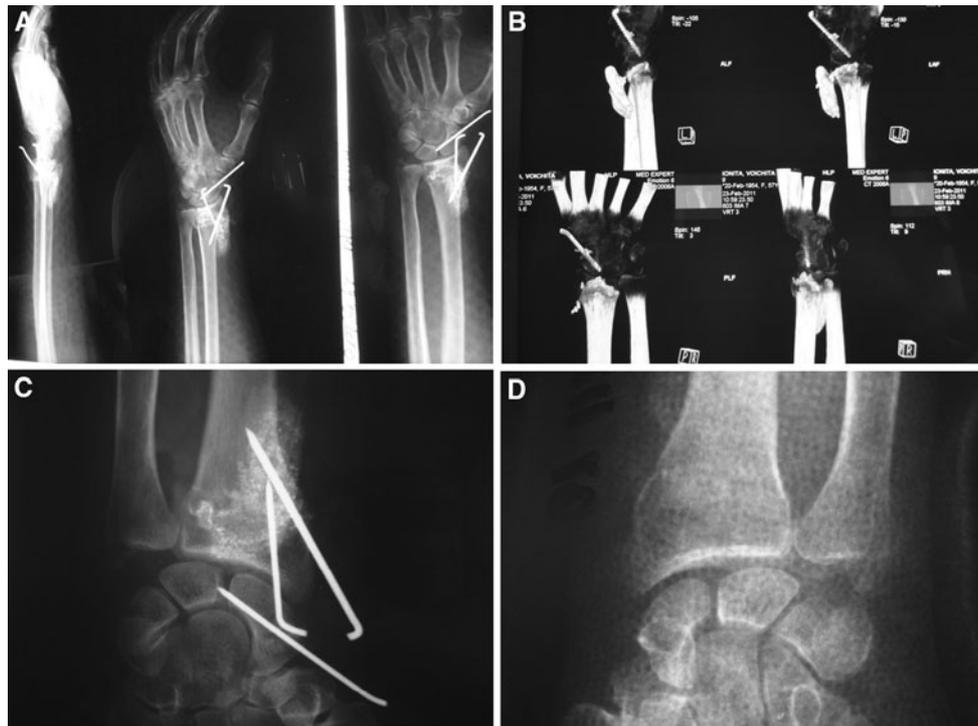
Distal radial fracture associated with a carpal scaphoid fracture—orthopaedic reduction, percutaneous temporary fixation with K-wires of the 2 fractures (a), CT control (b), X-ray control (c), and final result (d)
